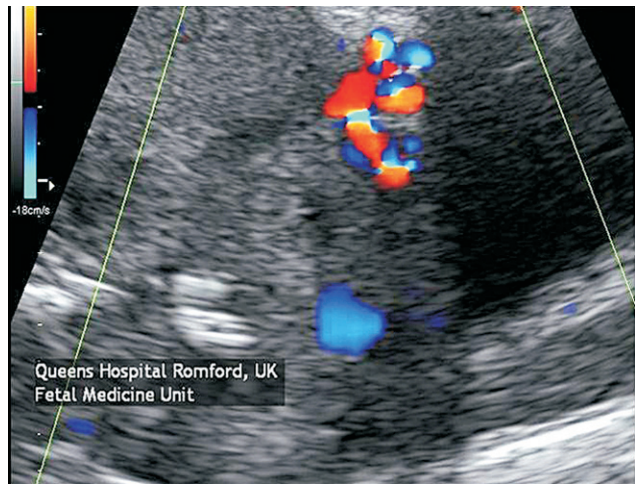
Color Doppler image of placenta accreta
